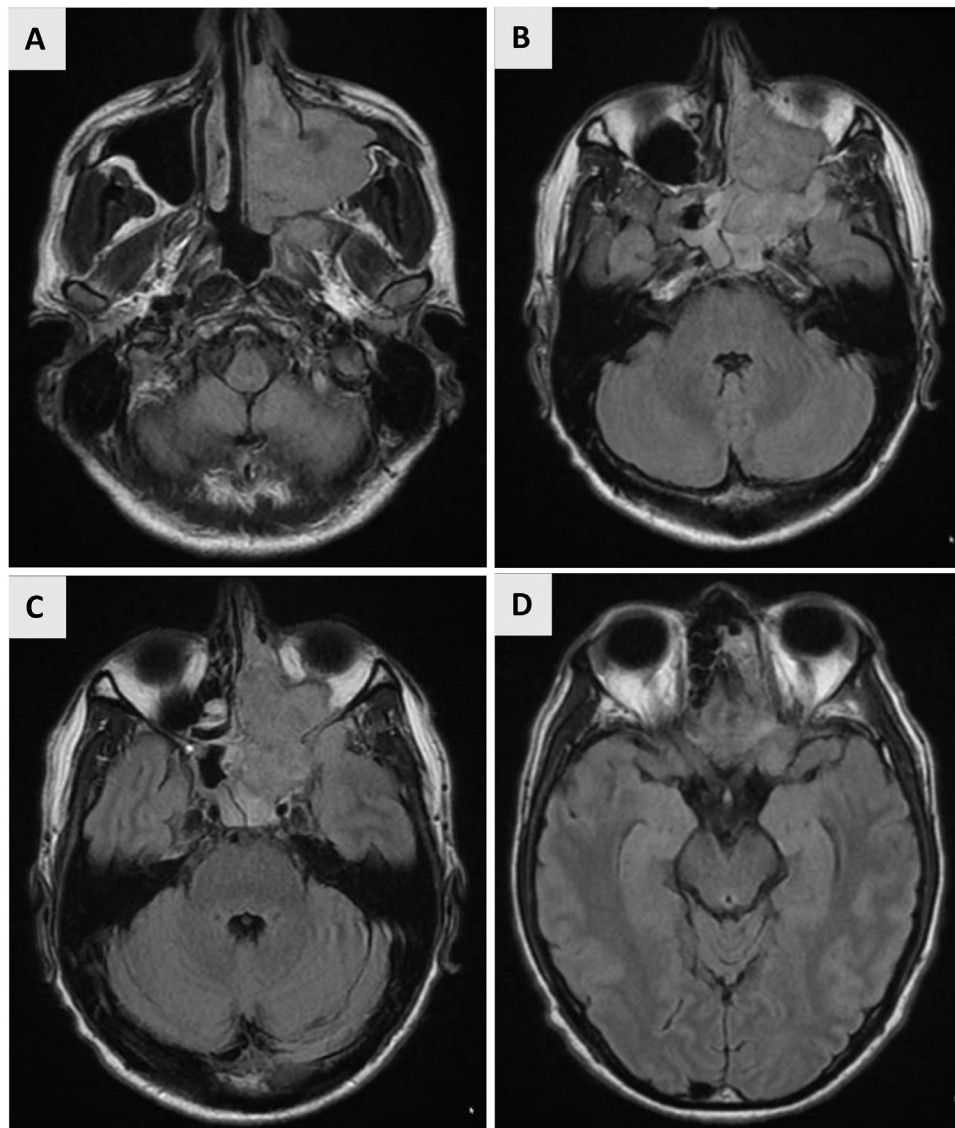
Axial noncontrast MRI cross sectional study of the head on admission. (A) The mass is centered within the region of the left pterygopalatine fossa extending into the left nasal cavity, left maxillary sinus, left anterior and posterior ethmoid air cells left sphenoid sinus, and left retromaxillary region. (B) The mass extends through the nasal septum to the right ethmoid sinus. (C) The intra-orbital left optic nerve has been compressed by the mass. (D) The intra-canalicular optic nerve has also been compressed while the intracranial and chiasmal segments of the left optic nerve are intact.
